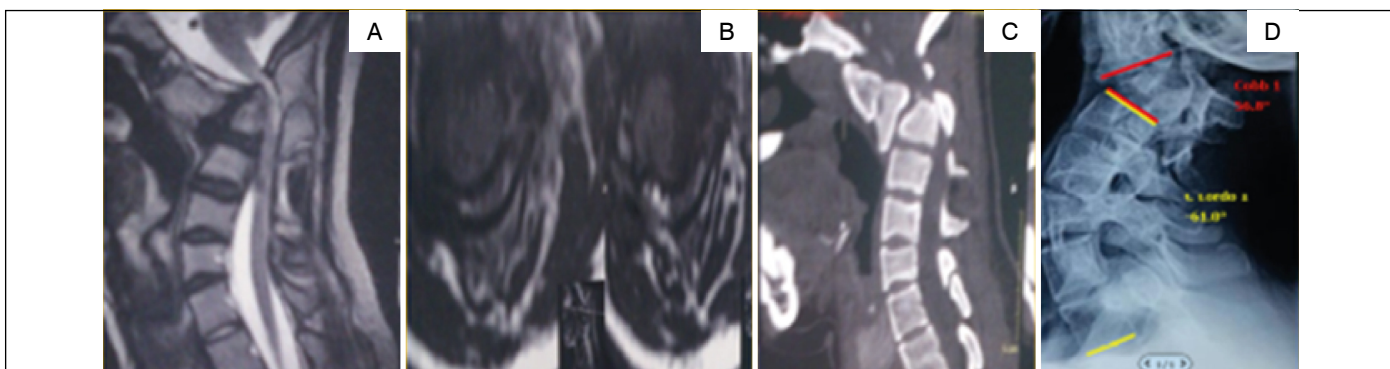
A and B - MRI sagittal and axial views showing severe medullary compression. C and D - CT scan and X-ray showing congenital kyphosis.
